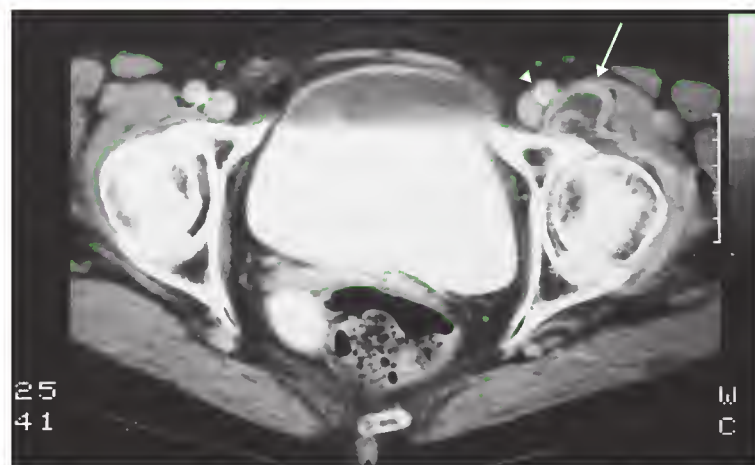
A computed tomography scan of a patient with rheumatoid arthritis shows an enlarged fluid-filled iliopsoas bursa (arrow) communicating with the hip joint and displacing the neurovascular bundle (arrowhead). (With permission from Letourneau L, Dessureault M, Carette S. Rheumatoid iliopsoas bursitis presenting as unilateral femoral nerve palsy. *J Rheumatol* 1991;18:462-3.)
